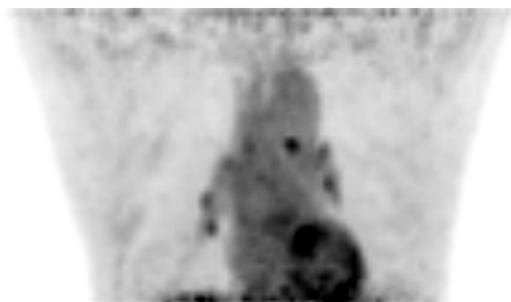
PET CT showed no hot uptake in the whole body at Oct. 2010
